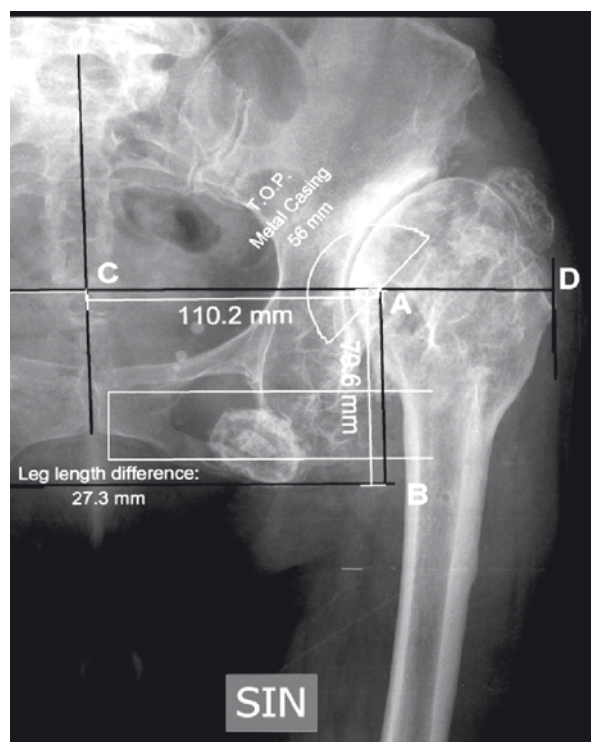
A-P radiograph of the pelvis– Crowe –type III dysplastic OA of the left hip joint(point A– the planned rotation center of the hip joint after THR;AB– the planned location of the vertical RC; AC–the planned location of the horizontal RC)
